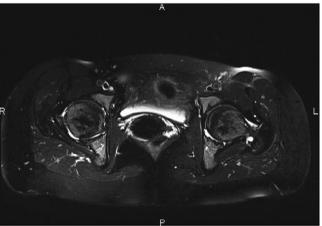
MRI of the hips. Case 1.
